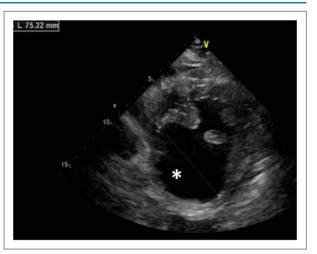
Transthoracic echocardiography (short axis view) suggestive of a pseudoaneurysm of the lower left ventricular wall (asterisk).
